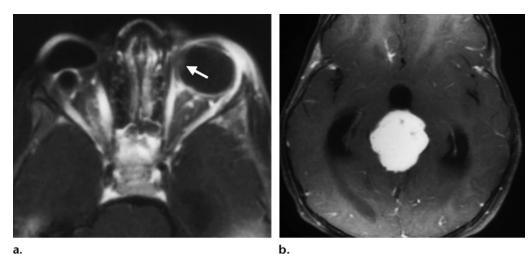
Trilateral retinoblastoma in a 2-year-old girl with a history of enucleation for retinoblastoma. (a) Axial postcontrast fat-saturated T1-weighted MR image shows a focus of enhancement along the medial wall of the left globe (arrow), a finding consistent with retinoblastoma. The right globe was removed due to retinoblastoma, and a prosthesis is in place. (b) Axial postcontrast T1-weighted MR image shows an associated enhancing pineoblastoma with resultant hydrocephalus.
